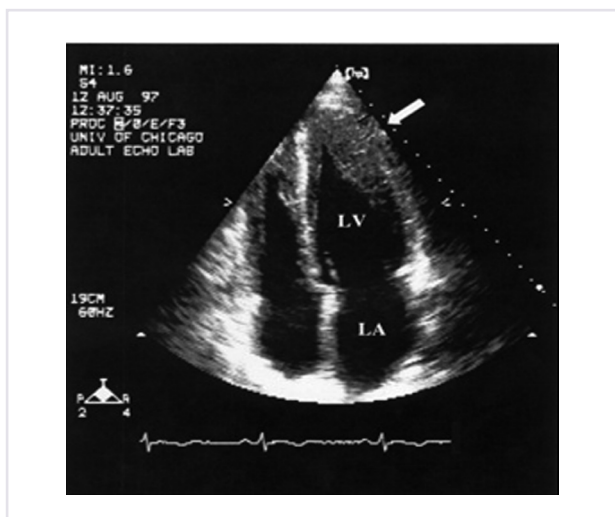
On 2-dimensional echocardiography, an apical 4-chamber view of the left ventricle showing hypertrophy of the apex in an "ace-of-spades" configuration
